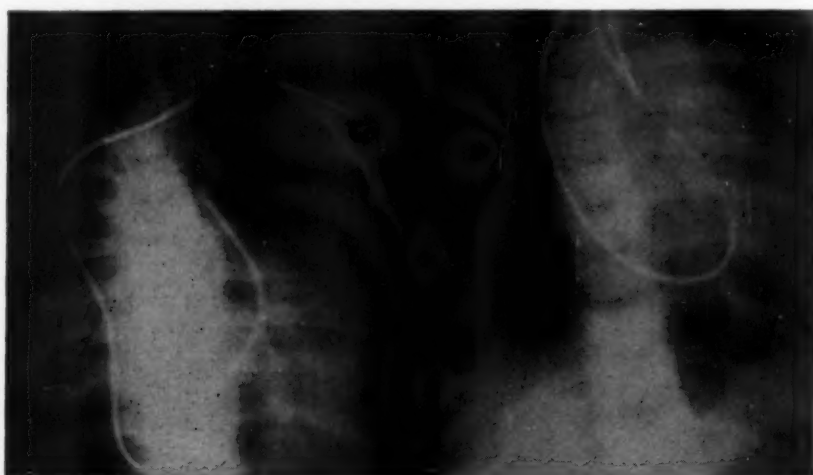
Radiography made during the catheterization of the pulmonary artery and the aorta.
